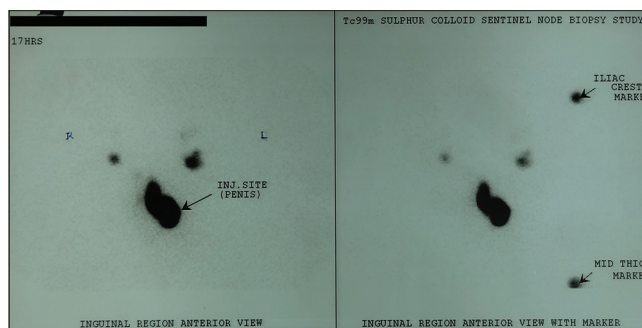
Pre-operative scintigraphy showing nodal uptake
